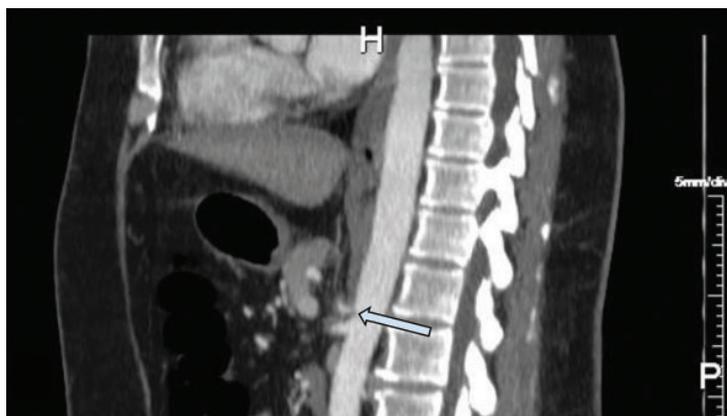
Contrast-enhanced computed tomographic angiography, sagittal (top) and 3-D coronal (bottom) views, showed severe stenosis at the origin of the celiac artery (arrow) with associated soft-tissue attenuation, suggestive of median arcuate ligament syndrome.
